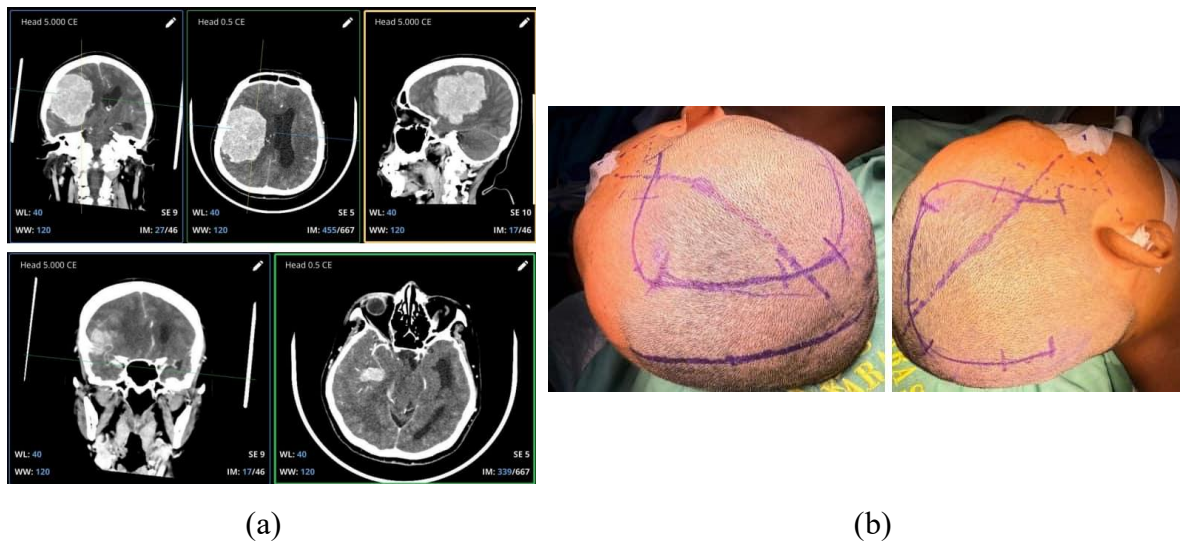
Tumor location and surgical approach. (a) Pre operative CT-Scan image for tumor observation (b) Patient positioning (Private documentation)
